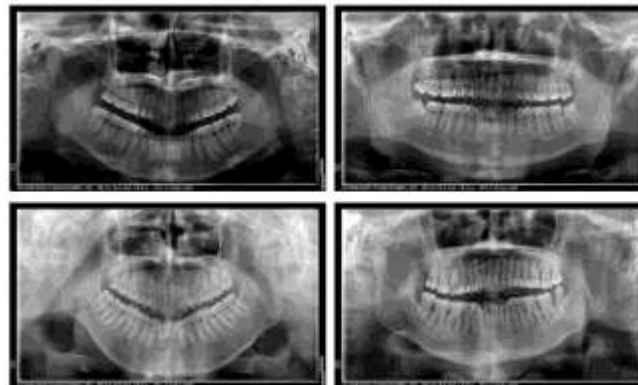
Panoramic Radiographic Image
